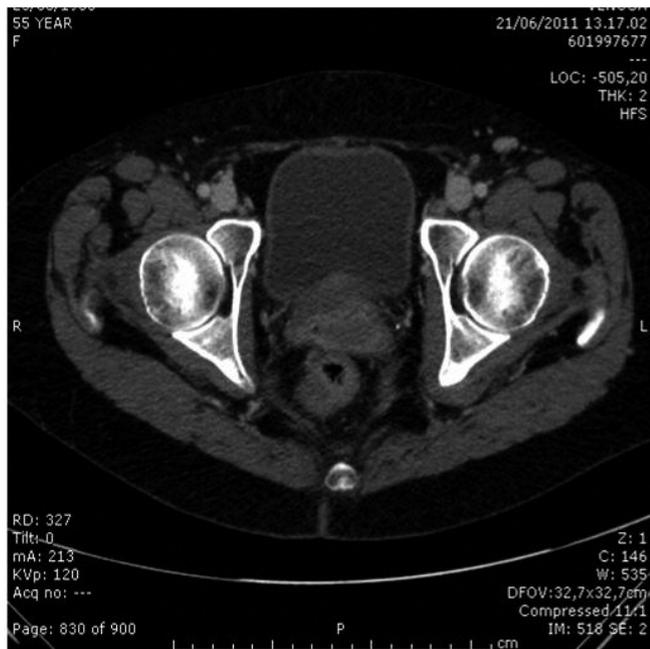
Total-body computed tomography (CT) scans; a 5-cm mass around the urethra.
